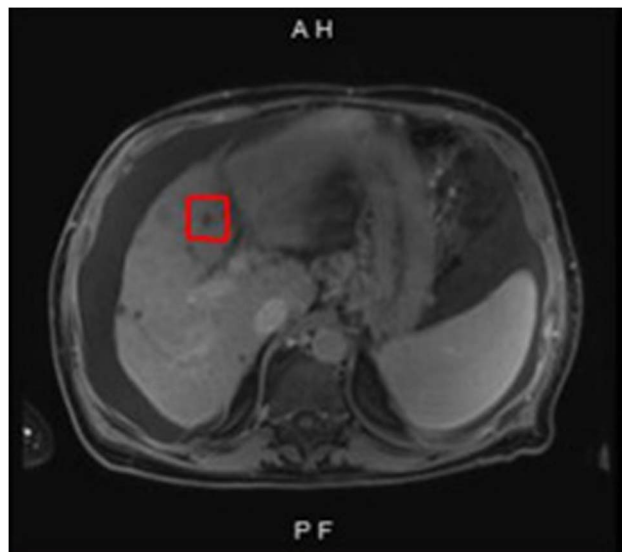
2 LIRADS-3 (LR3) hepatic lesion in segment 4a—MRI.
